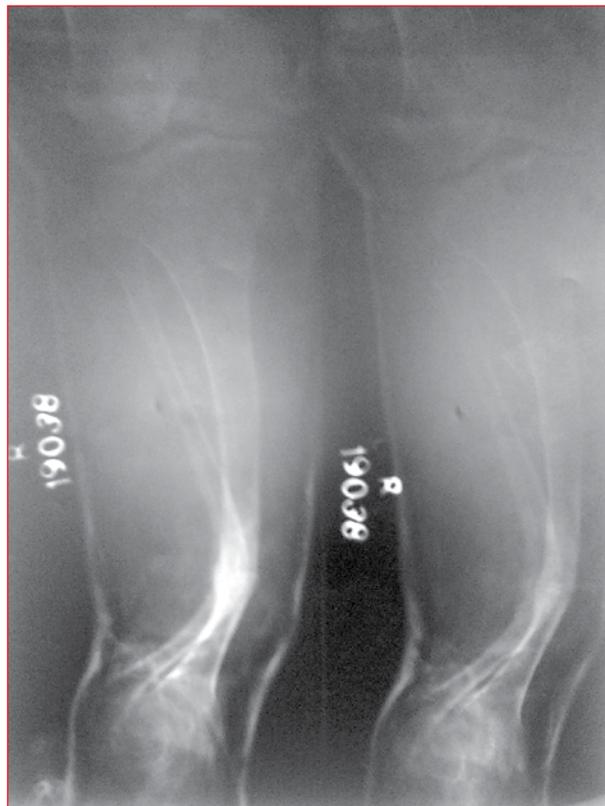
An X-ray showing valgus deformity of the leg
